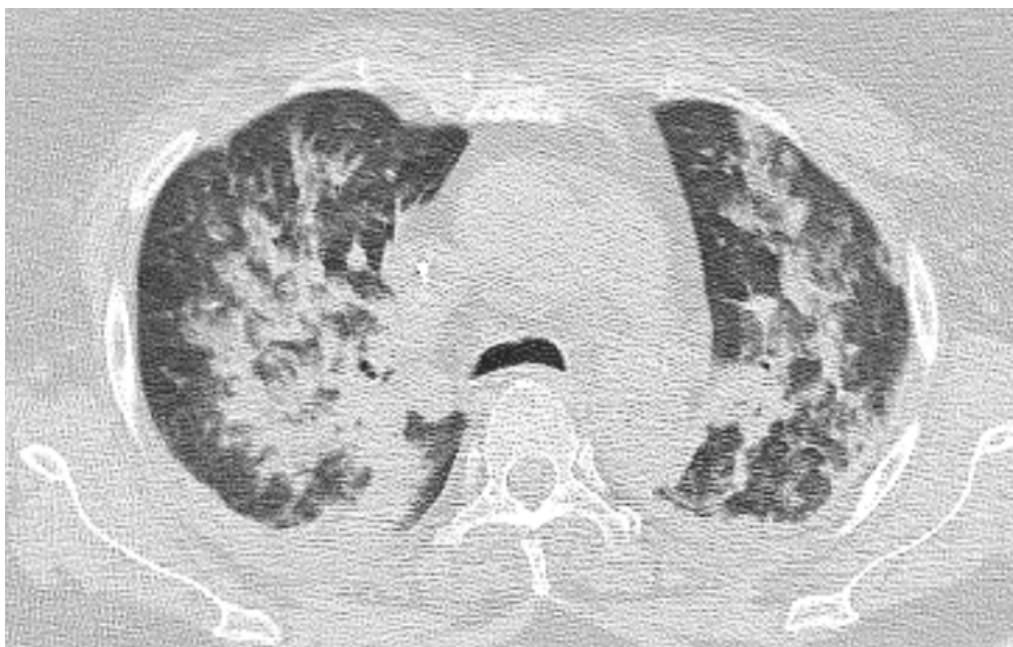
Chest computed tomography showing bilateral parenchymal condensations suggestive of COVID-19 pneumonia
